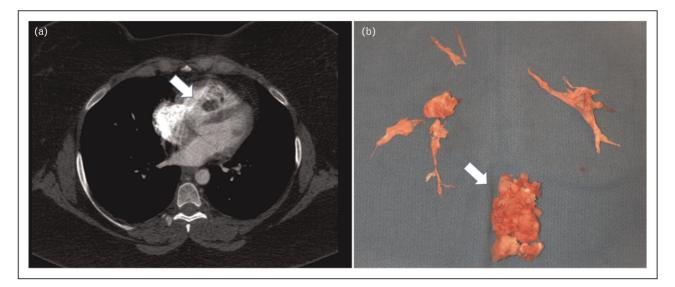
Patients presenting with acute haemodynamic shock due to an organized clot in transit obstructing the right ventricular outflow tract. (a) CT scan demonstrates the clot in the right ventricle (arrow). (b) Pulmonary thrombo-endarterectomy was performed with resection of the organized thrombi in the right ventricle (arrow).
